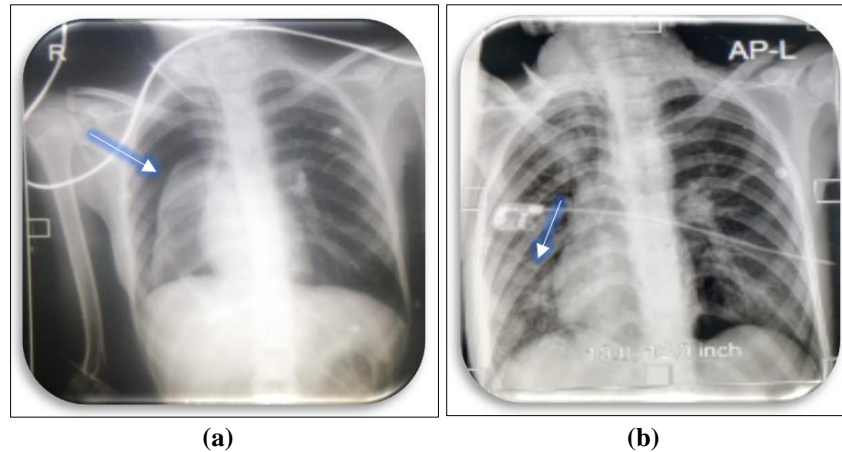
a) Chest X-ray showing large right Pneumothorax, b) Improvement in pneumothorax after thoracic drainage (arrow)
